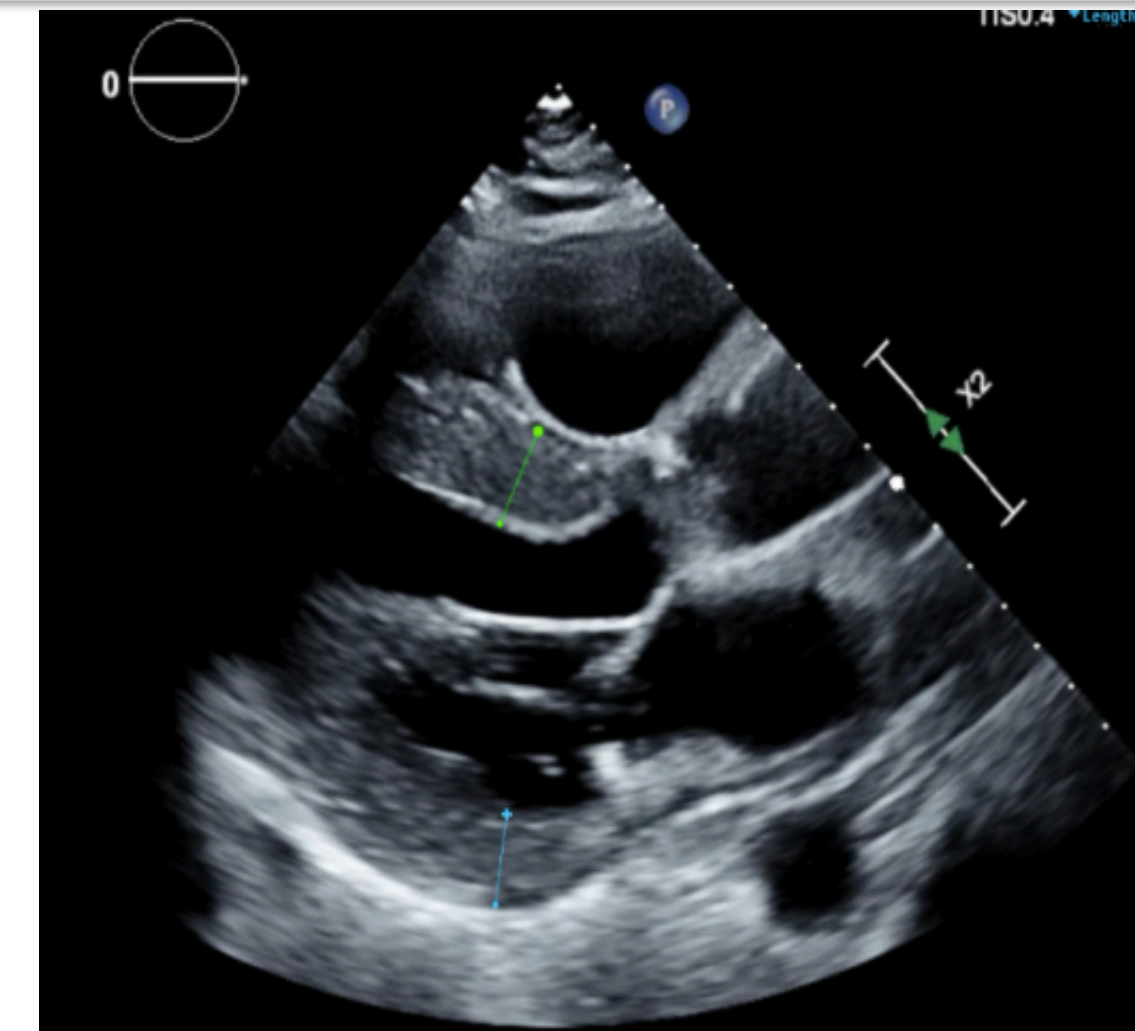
Echocardiogram showing diffuse LV wall thickening
